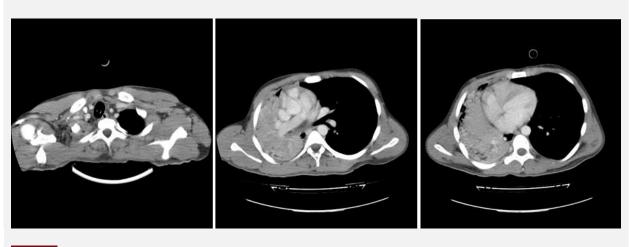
Spiral axial chest computed tomography scan 🏦
